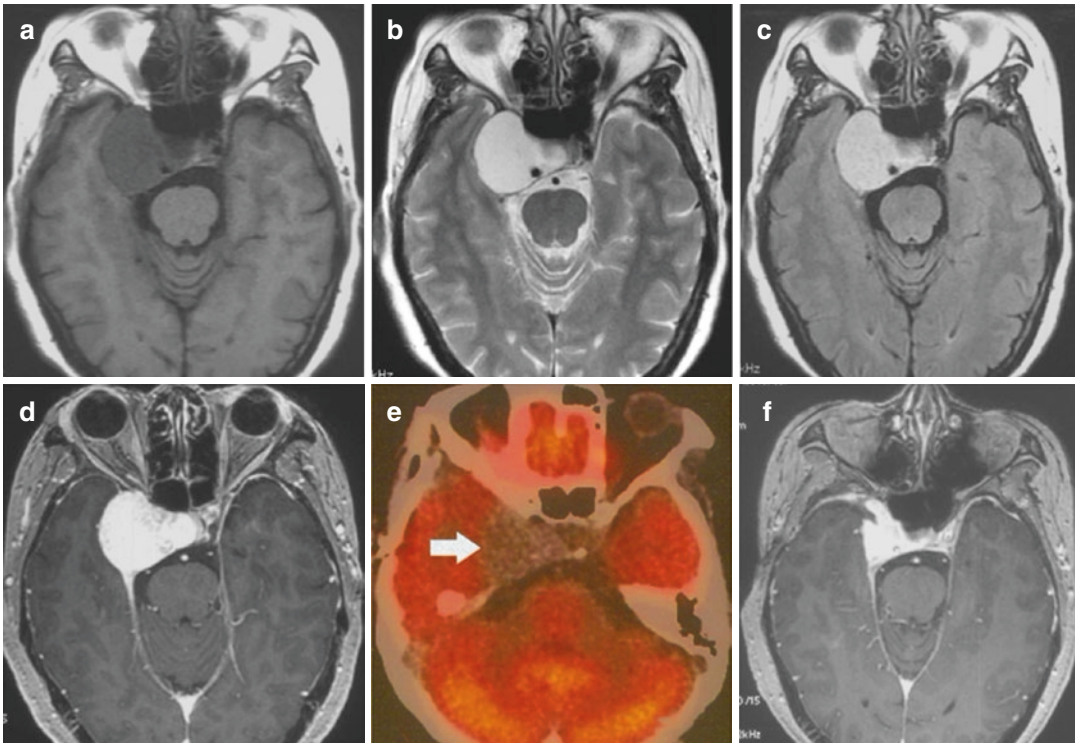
MR images of a representative case showing radiological characteristics of CSH. A 50-year-old male patient suffered from slight headache and went for an MR scan, which showed a sharply delineated iso- or hypo-signal mass lesion on T1-weighted images (a), extremely high signal on T2-weighted images (b) and FLAIR sequence images (c), and intensely enhanced sellar mass
